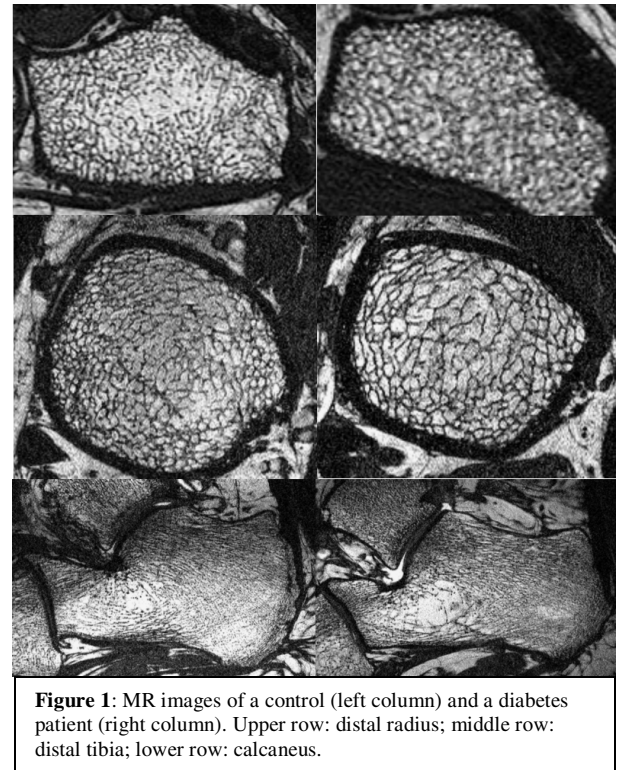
MR images of a control (left column) and a diabetes patient (right column). Upper row: distal radius; middle row: distal tibia; lower row: calcaneus.
